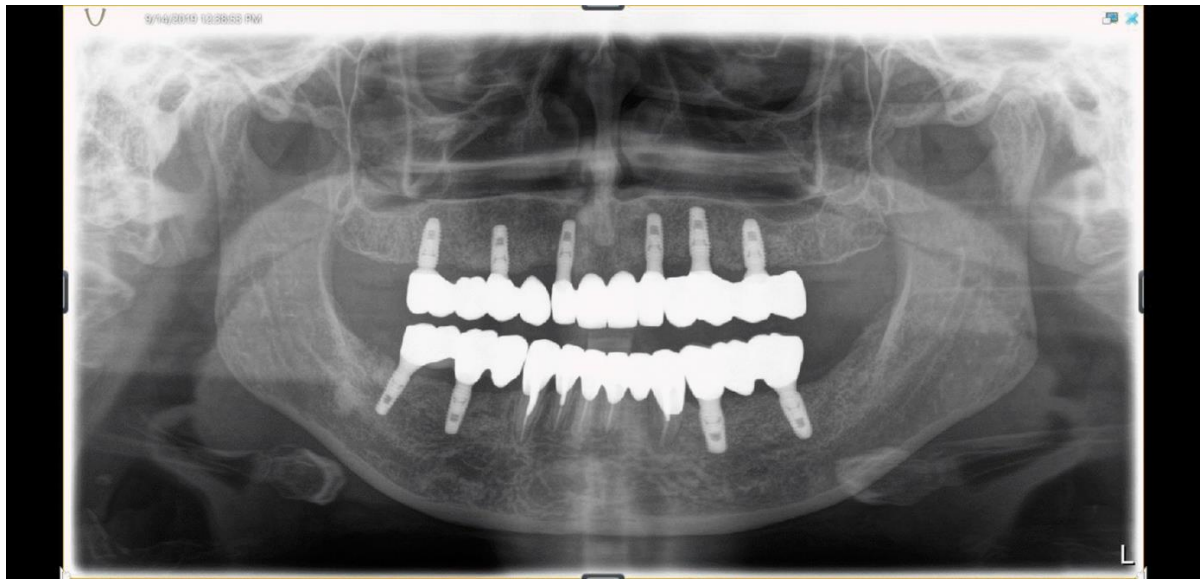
Panoramic X-ray after prosthetic rehabilitation, showing well osseointegrated loaded implants.
